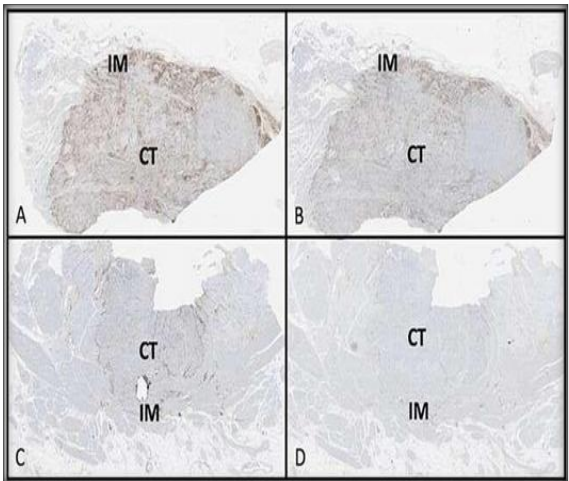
High vs. low density and locations of CD3 & CD8 (A) High concentration CD3 in CT and IM. (B) High concentration CD8+ in CT and IM. (C) Low concentration CD3+ in CT and IM. (D) Low concentration CD8+ in CT and IM
